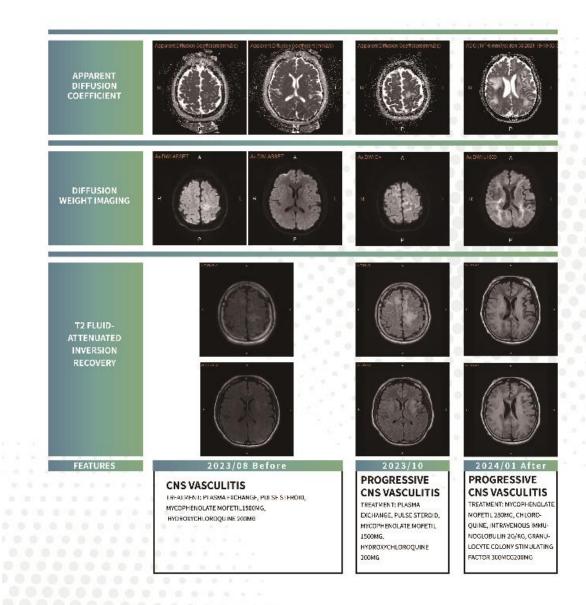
MRI progression in a 40-year-old female with SLE and CNS vasculitis evolving into JC virus-related progressive multifocal leukoencephalopathy (PML). Serial axial MRI images from 2023/08 to 2024/01 demonstrate progressive white matter changes.
